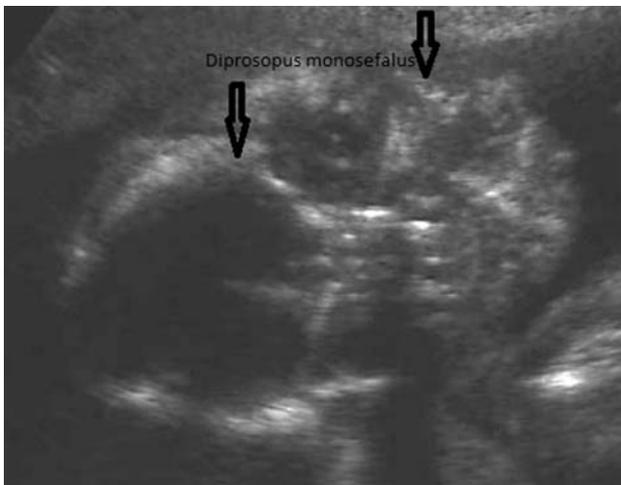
Ultrasonographic view of double-face, single head.
